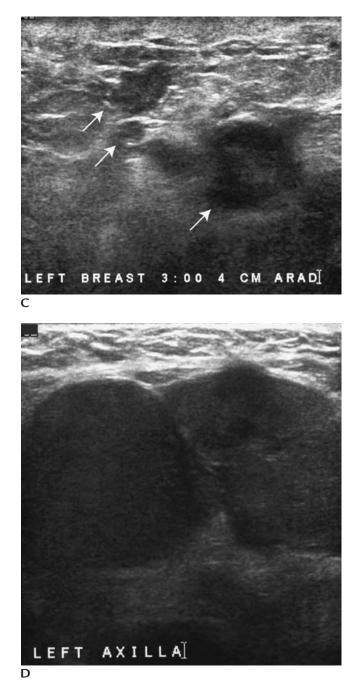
(*Continued*) (C) Although not all patients presenting with inflammatory carcinoma will have a demonstrable focal abnormality on ultrasound that can be biopsied, in this patient, multiple masses (*arrows*) are identified laterally in the left breast. Skin thickening is also present. (D) As suspected mammographically, multiple hypoechoic masses are confirmed sonographically in the left axilla. An ultrasound guided core biopsy is done to establish the presence of metastatic disease to left axillary lymph nodes.
